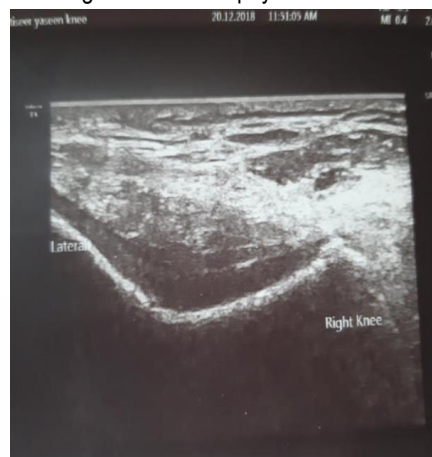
Transverse view of musculoskeletal ultrasound of right knee showing Cartilage thickness grade 2a and osteophyte
